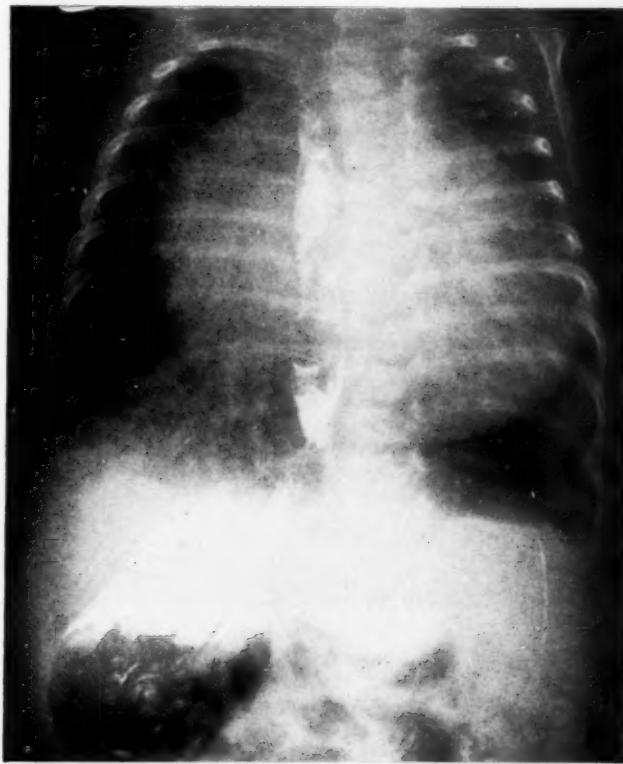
Posteroanterior roentgenogram of the chest showing marked enlargement of the heart and, incidentally, dextroposition of the stomach.
